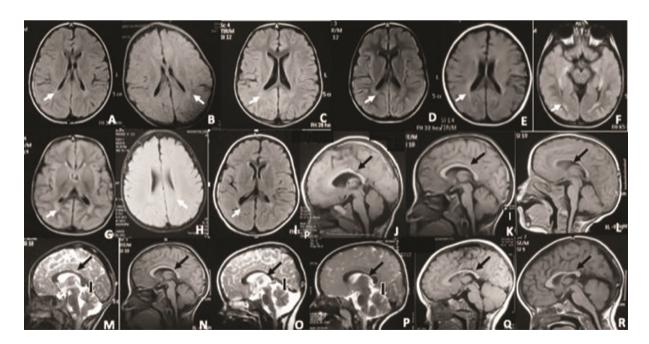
Brain MRI lesions in the studied patients. Axial T2W-FLRAIR cuts showing variable degrees of deep periventricular white matter signal mainly around the occipital horn of lateral (white arrow) (A–I). Sagittal T1W andT2W cuts showing thin corpus callosum especially the body (J–R) (long black arrow) and vermian atrophy (M,P) and hypoplasia (O) (short black arrow).
